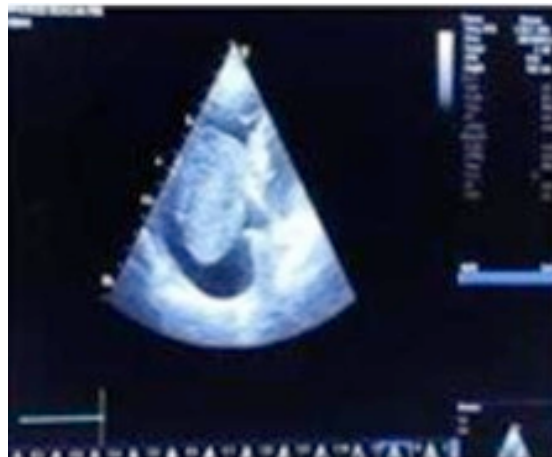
A huge pedunculated mass attached to RA free wall on Two-dimensional echocardiography
